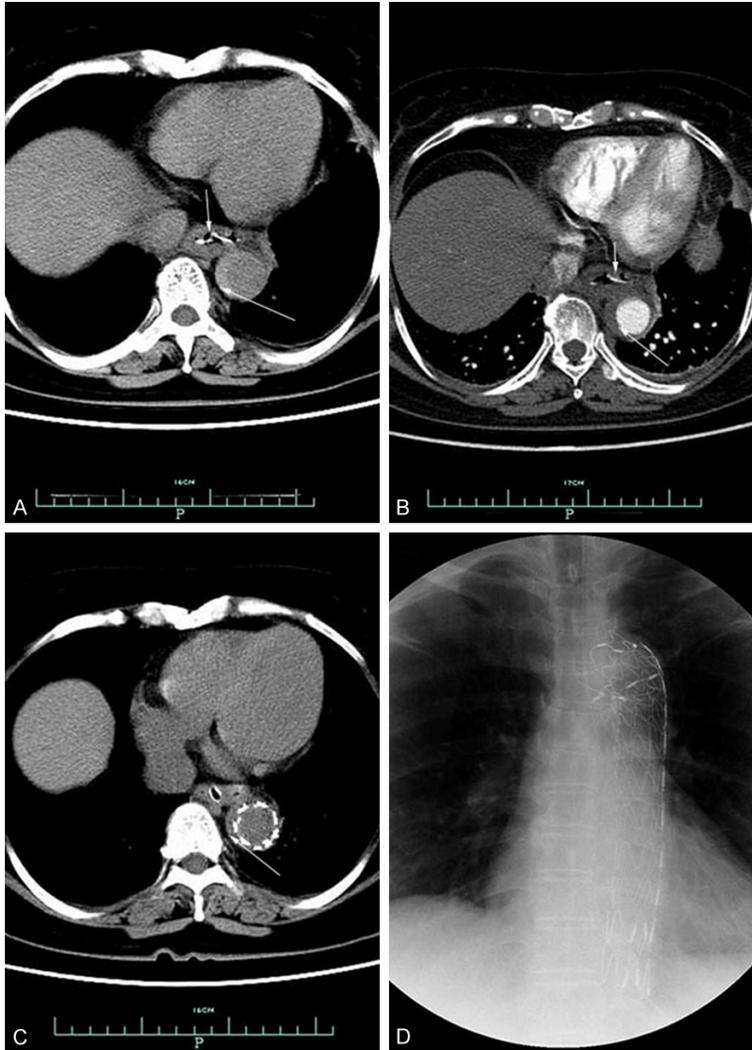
(Case 2), CT scan showed a foreign body (short arrow) retained in the lower esophagus and abnormal shadow of hyperdense (long arrow) surrounding the aorta (A). CTA also showed the foreign body (short arrow) and shadow of hyperdense (long arrow) surrounding the aorta, and no signs of inflammation surrounding the aorta and esophagus (B). CT postoperatively showed reduced shadow of hyperdense (arrow) surrounding the aorta, no signs of inflammation and the stent graft had normal morphology (C). X-chest postoperatively showed the stent graft had normal morphology (D).
